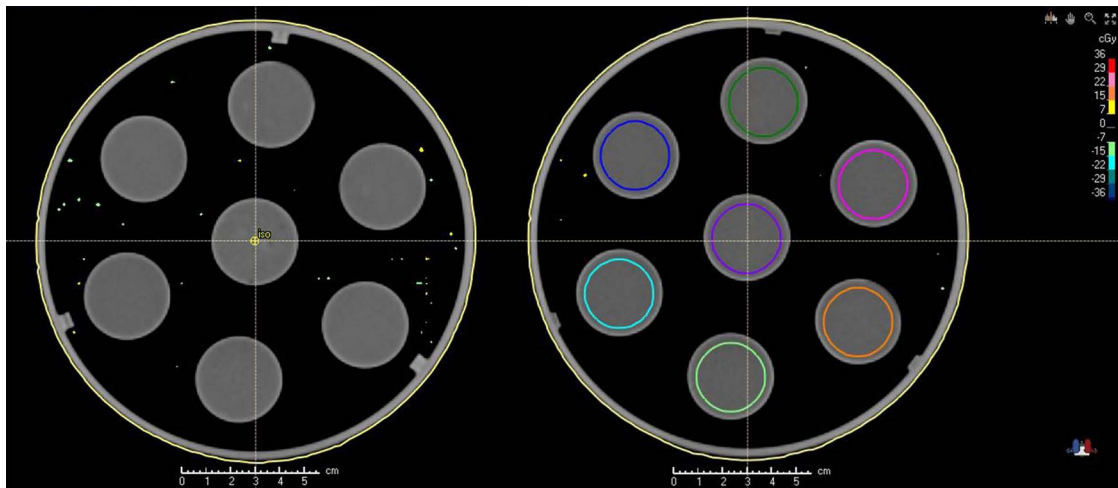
Dose difference from CT and MR image-based dose distribution. Two slice images were selected and the relative dose scale on the figure was selected from  $-5, -4, -3, -2, -1, 0, 1, 2, 3, 4, 5\%$  for maximum dose.
